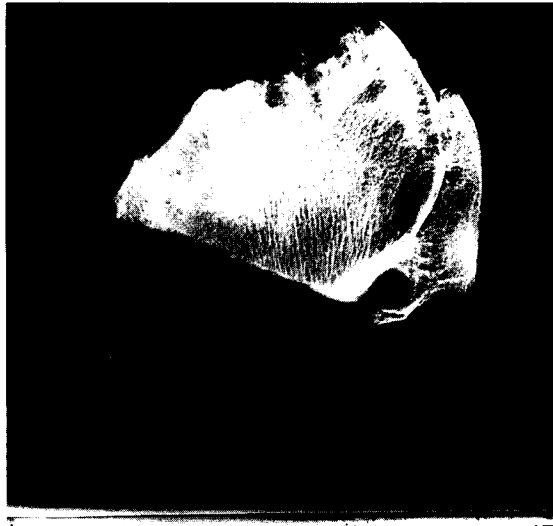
Anteroposterior radiograph and autoradiograph of slab of femoral head.
